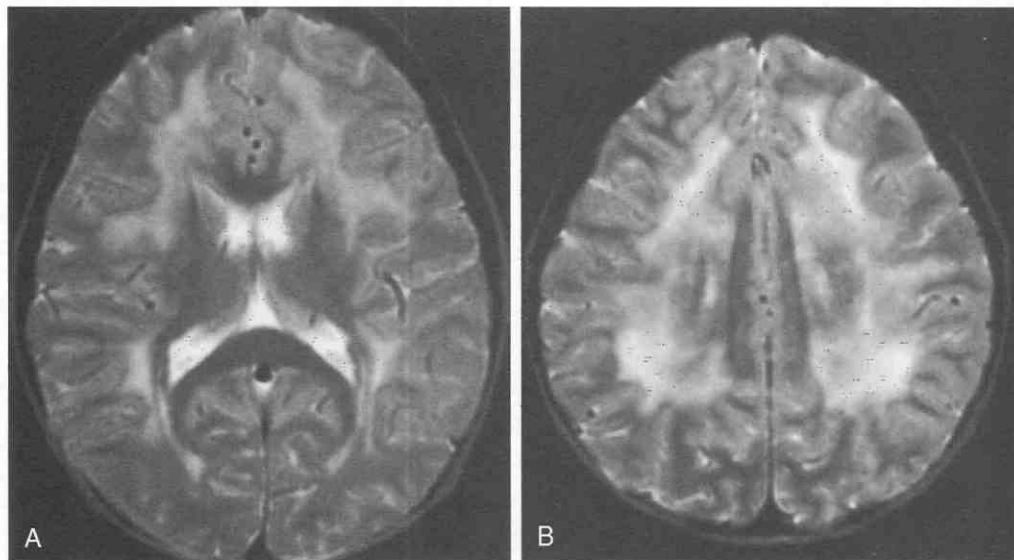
Leukoencephalopathy secondary to multiagent chemotherapy for acute lymphocytic leukemia without radiotherapy. A and B, T2-weighted axial cranial MR images show diffuse, mild hyperintensity in the deep white matter bilaterally. Despite the MR appearance, this patient had minimal neurologic signs and was doing well in school.
